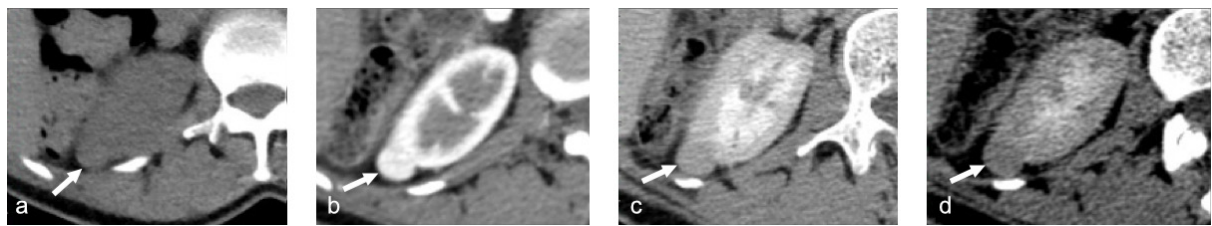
Multiphase contrast-enhanced axial CT scan of the abdomen exhibiting a small renal oncocytoma on the right kidney. Renal tumour of solid character on the native phase (a) shows contrast uptake (b) on the corticomedullary phase with subsequent washout (c, d) on later nephrographic and excretory phases. Contrast uptake and washout is common imaging characteristic for renal oncocytomas and RCCs. (*Karolinska University Hospital Huddinge, MIDOR study*)
